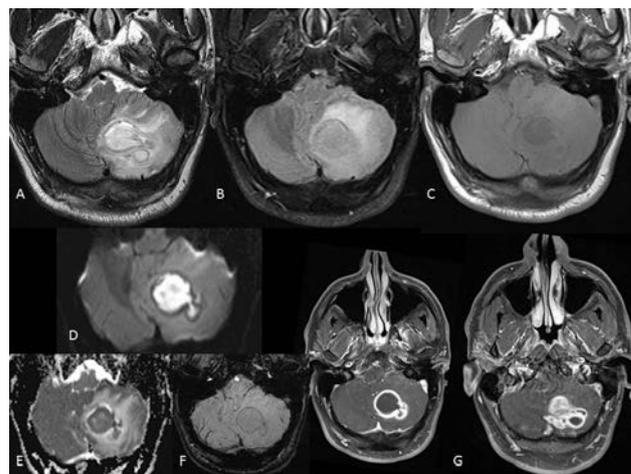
T2WI, B-FLAIR, C-T1WI, D-DWI, E-ADC, F-SWI, G- Post contrast T1WI. Peripherally rim enhancing lobulated lesion with central diffusion restriction is seen in the left cerebellar hemisphere. The dual rim sign suggestive of an abscess is seen on T2WI and SWI. Mass effect with effacement of the adjacent sulcal spaces, 4th ventricle, the left CP angle cistern and mild tonsillar descent.
